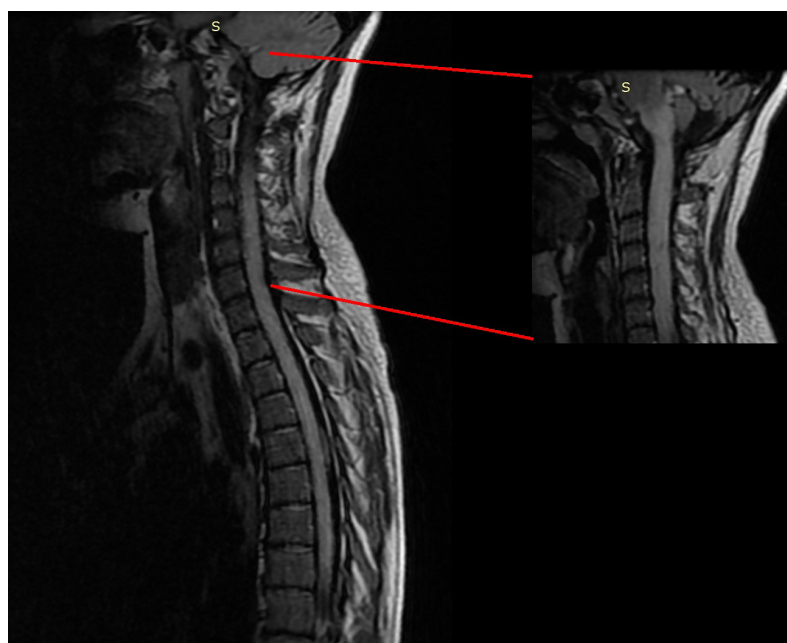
Sagittal plane MRT FLAIR image: diffuse hyperintensity of the spinal cord up to the level of bulbo-pontine transition (magnified image included).
